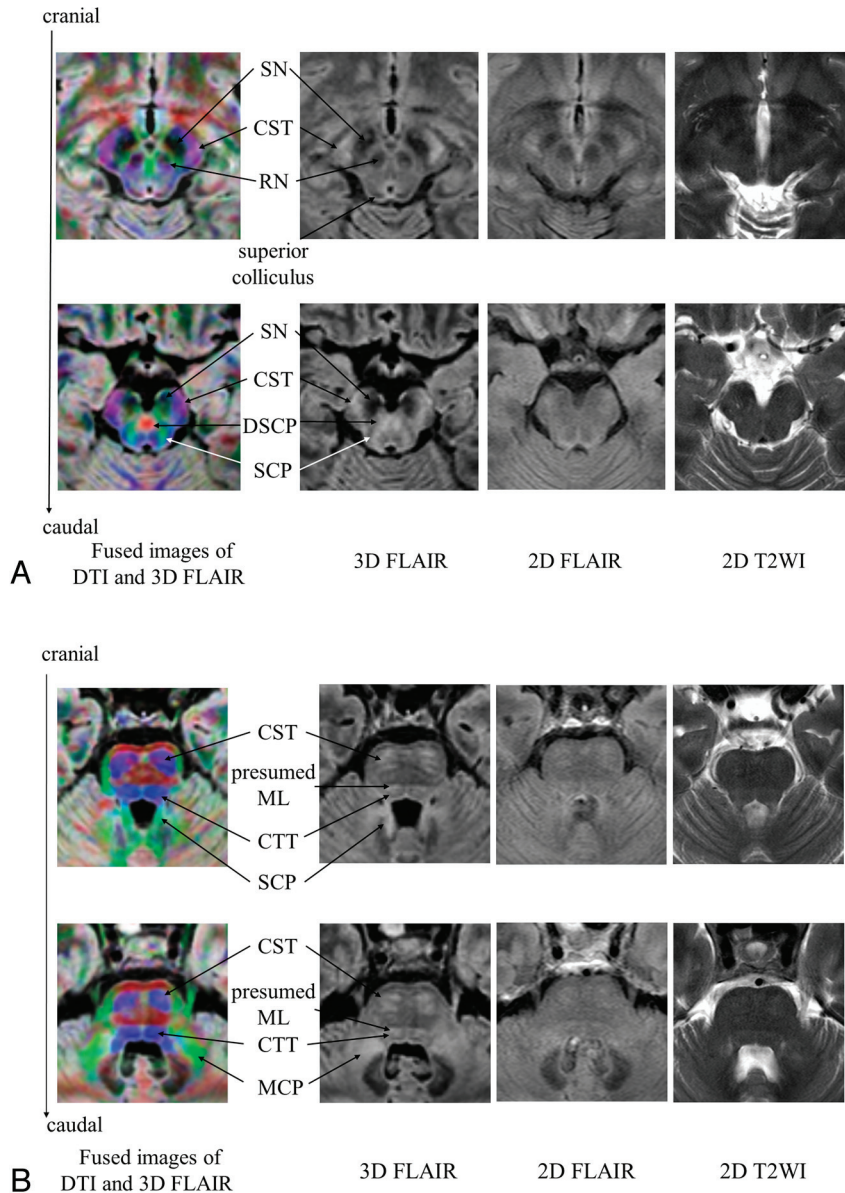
Midbrain and pontine anatomy. *A*, Midbrain: left column, fused images of 3D FLAIR and color maps; 2nd column from left, 3D FLAIR images; 3rd column, corresponding sections on 2D FLAIR images; right column, corresponding sections on 2D T2WI. Blue indicates superior-inferior orientation; green, anteroposterior orientation; red, laterolateral orientation. *B*, Pons: Left column, fused images of 3D FLAIR images and color maps; 2nd column from left, 3D FLAIR; 3rd column, corresponding sections on 2D FLAIR images; right column, corresponding sections on 2D T2WI. For color codes, see *A*.
